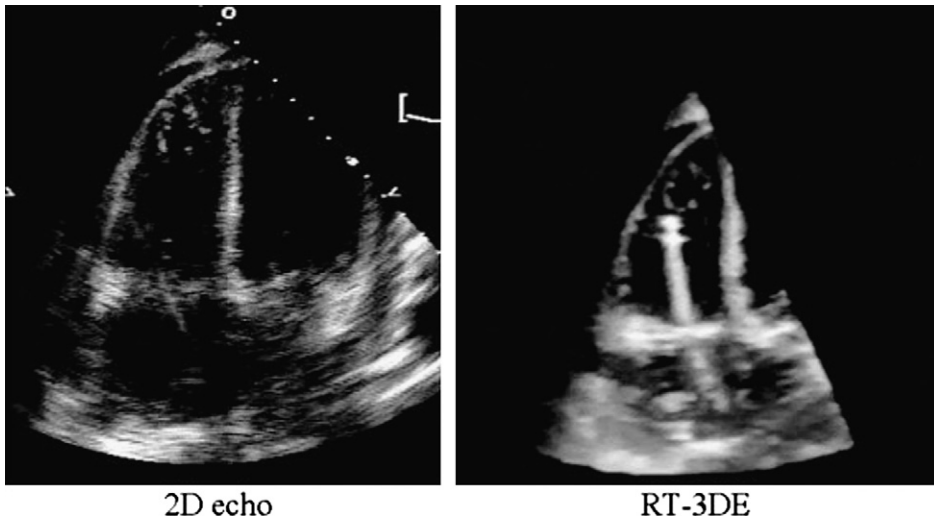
Example of 2D (*left*) and 3D (*right*) echocardiography of a right ventricular biopptome for performing endomyocardial biopsy. Note that as opposed to the 2D image, which shows only a partial view of the biopptome and poor visualization of the tip, the 3D image shows the complete biopptome and tip. (Courtesy of D. Liang, MD, PhD, Stanford, CA.)
